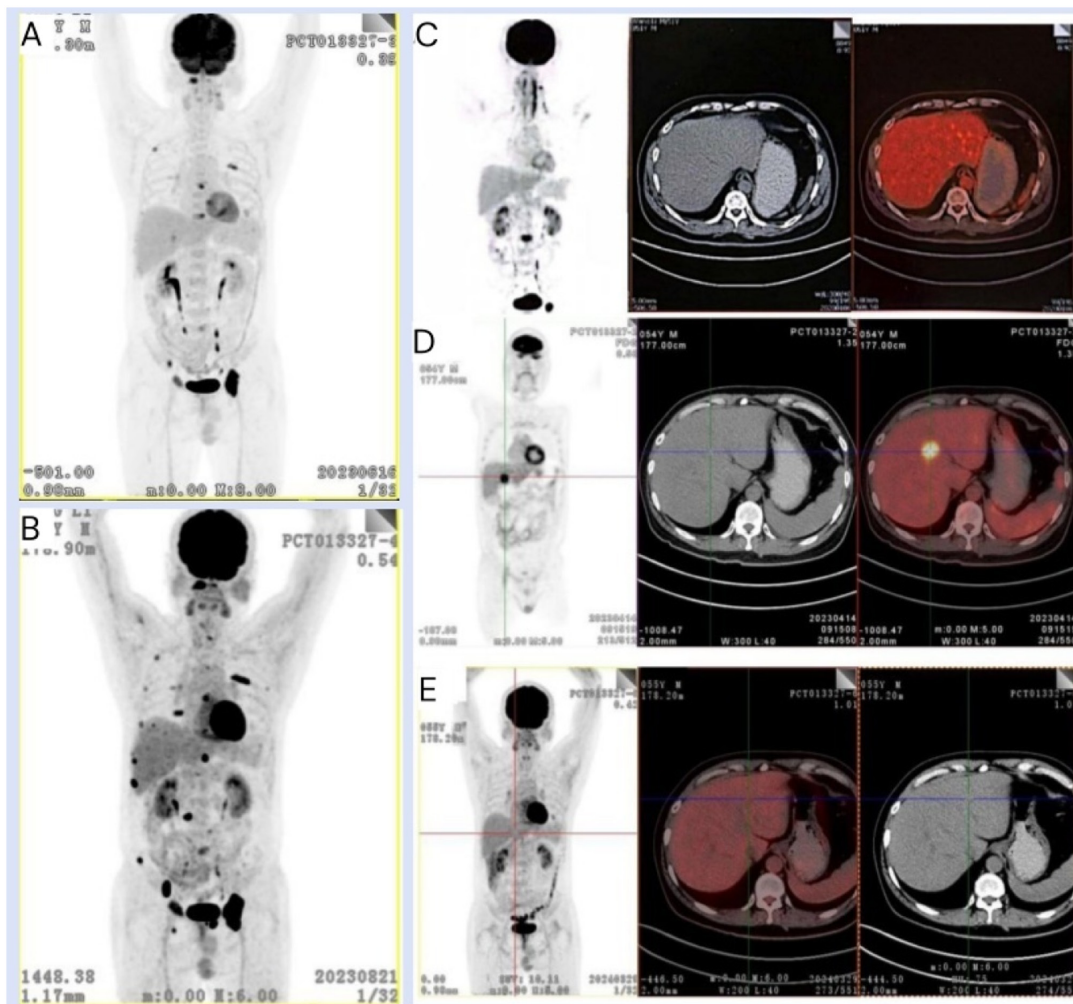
Whole-body PET/CT scans. (A) Osteolytic bone destruction lesions (June 2023). (B) Osteolytic bone destruction lesions increased (August 2023); (C) No lesion change in the S4 segment of the liver on diagnosis (December 2019); (D) Lesion changes in the S4 segment of the liver (April 2023). (E) Lesion changes in the S4 segment of the liver reduced with no hypermetabolism (March 2024). PET/CT, positron emission tomography/computed tomography.
